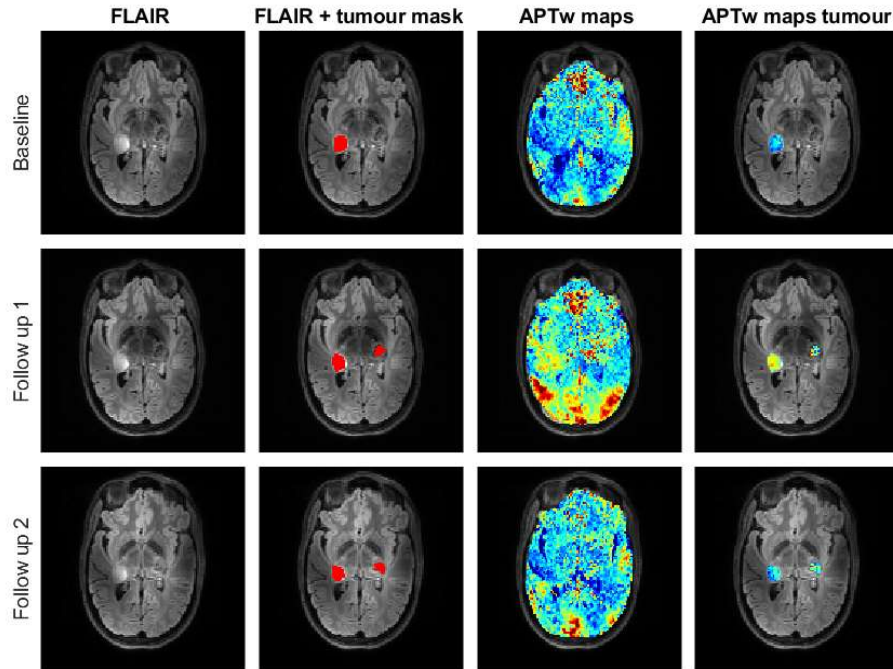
Example of the FLAIR image, tumour mask, APTw maps, and APTw values in the tumour of patient 3.
